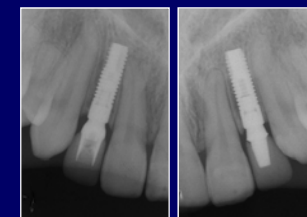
Radiographs 6 months after implant placement and immediate loading (implant 12: change of direct abutment to TI-design abutment)
